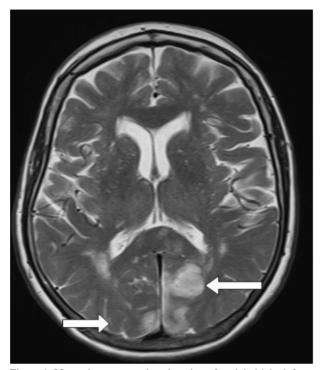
Magnetic resonance imaging view of occipital lobe infarct (Arrows)
